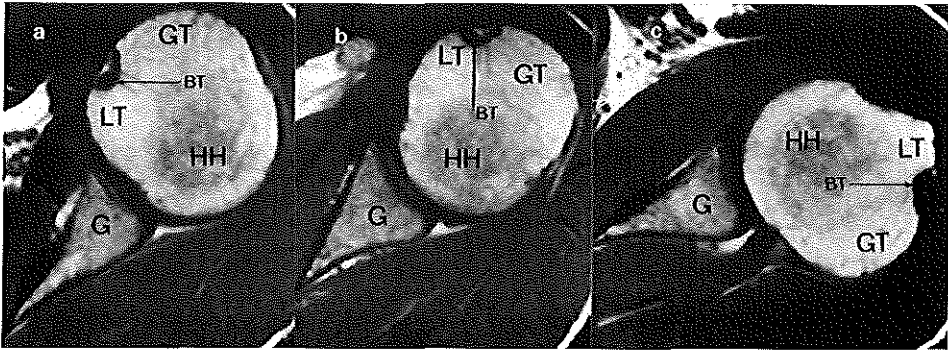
Magnetic resonance images (T1W) of a healthy male volunteer without complaints of the imaged shoulder. The upper part of the photographs represents the anterior side of the shoulder, the lower part the posterior side. Horizontal sections of the left shoulder in a. maximal internal rotation, b. anatomic position, and c. maximal external rotation. In maximal external rotation the bicipital groove lies posterior to the plane of the scapula. Compare with figure 5.4. BT=biceps tendon; G=Glenoid; GT=greater tuberosity; HH=Humeral head; LT=lesser tuberosity.
